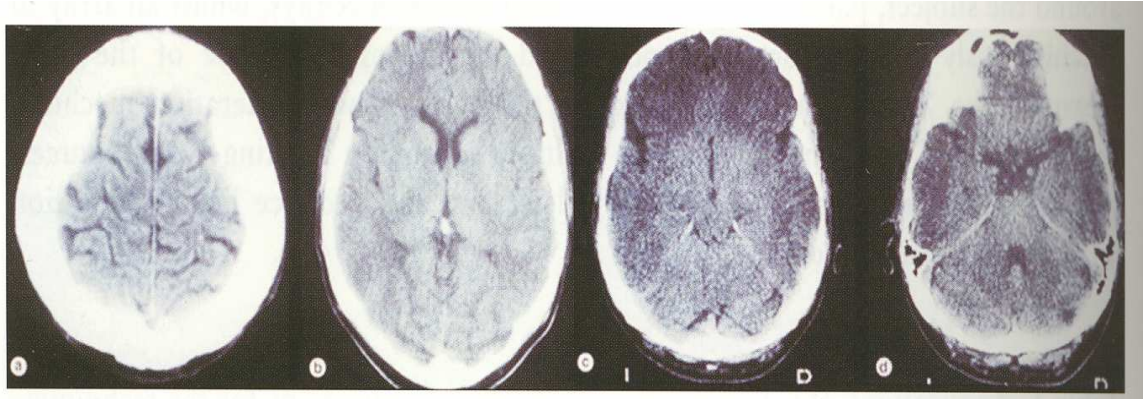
A CT scan of the living human brain. Whilst the skull and ventricles can be clearly distinguished from the underlying brain tissue, it is more difficult to distinguish between the grey and white matter of the brain. Image from Sharma and Chitnis (2000)
